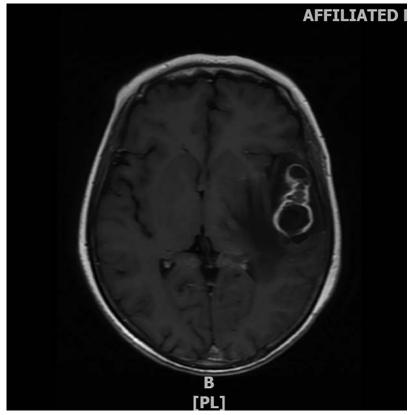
MRI T1-weighted postcontrast image demonstrating irregular ringlike contrast-enhanced lesions. MRI: magnetic resonance imaging.
